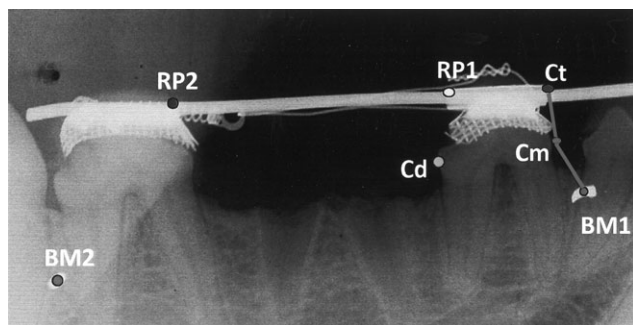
Radiographic landmarks and measurements including Cm, the most mesial point on the crown of the tooth; Cd, the most distal point on the crown of the tooth; Ct, the most superior/mesial point on the edge of bracket tube; BM1, the centre of the mesial bone marker; BM2, the centre of the distal bone marker; RP1, the superior intersection of the archwire and the distal of the bracket tube on second premolar; and RP2, the superior intersection of the archwire and the mesial of the bracket tube on the other banded tooth.
